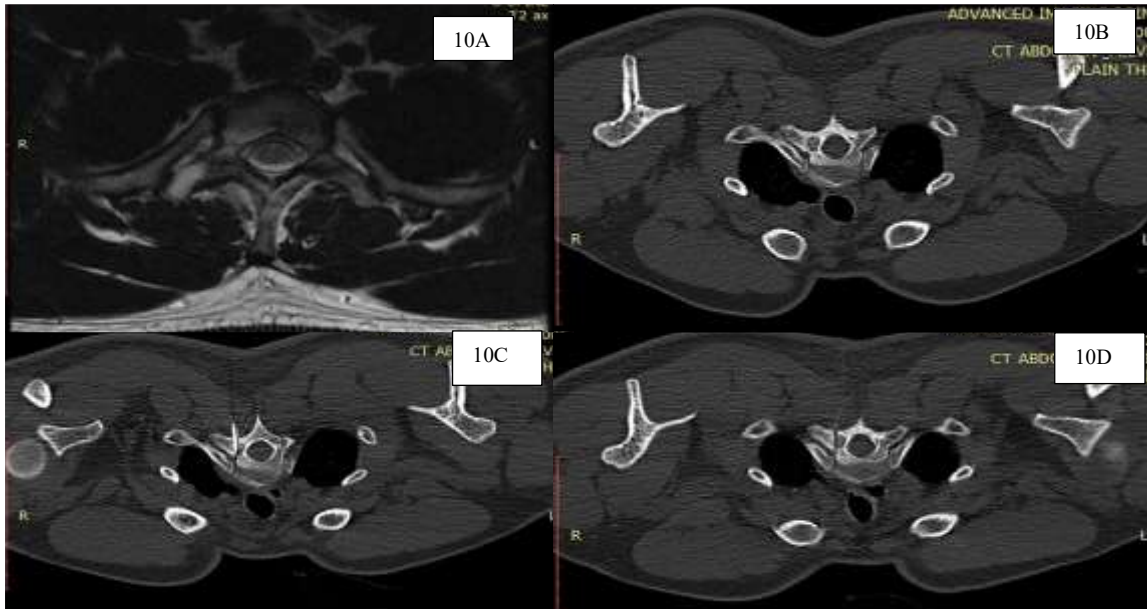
A and B: Axial MRI and CT of 22 year Male, respectively demonstrating osteoid osteoma in pedicle of vertebra.
